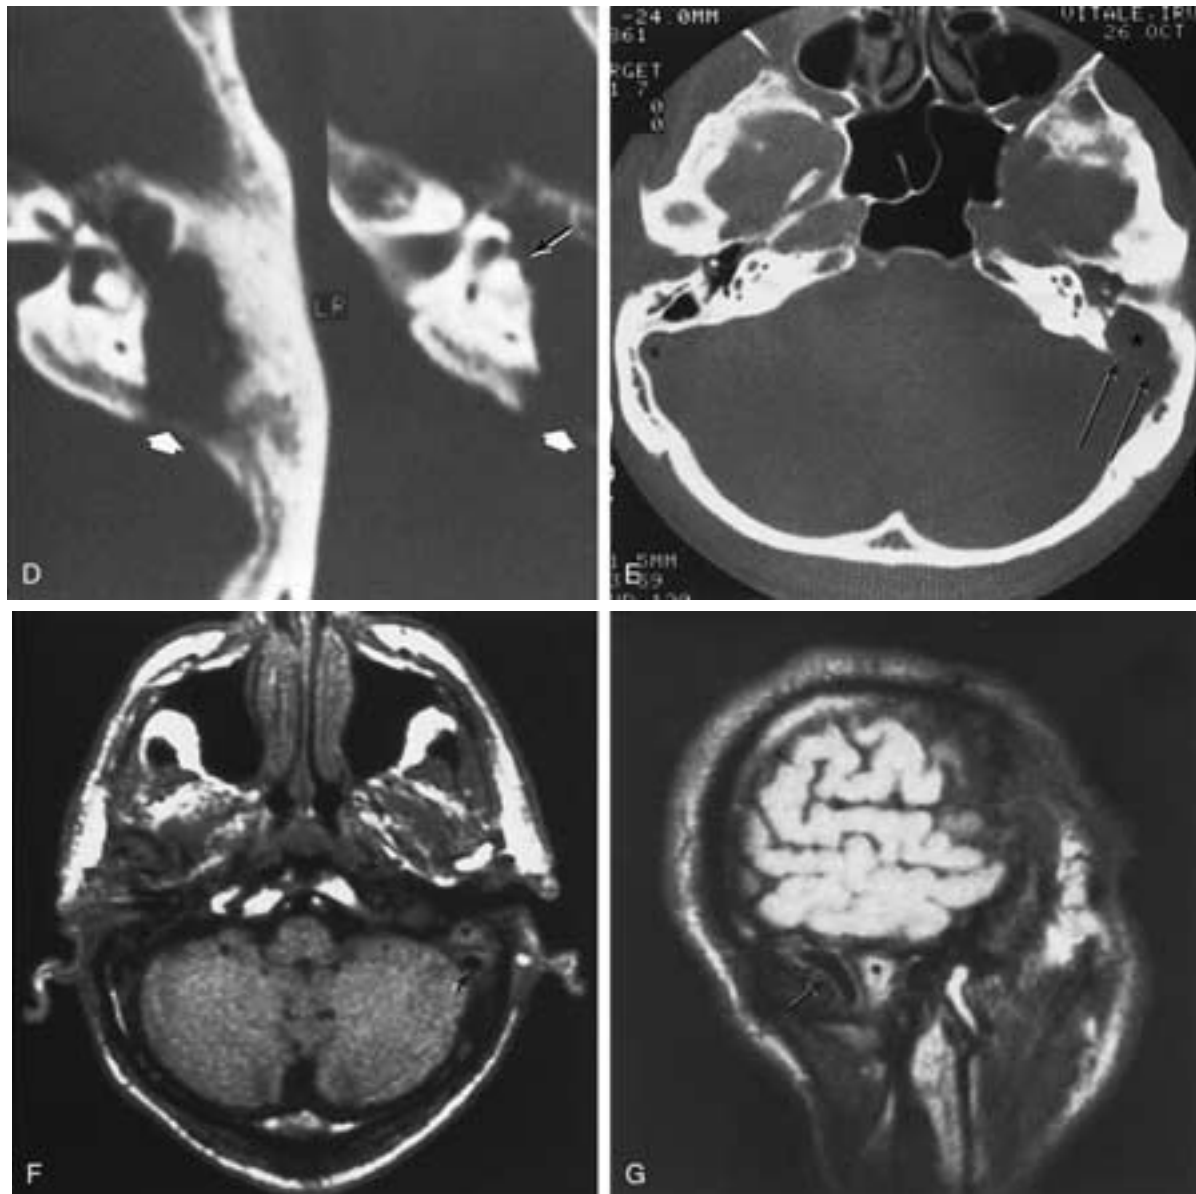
Continued D, In addition to the large fistula (*black arrow*), contiguous axial images demonstrate the presence of a defect in the sigmoid sinus plate (*white arrowhead*). E, Axial CT image on a different patient. Asterisk, Mastoid mass; arrows, sigmoid sinus plate defect. F, Axial T1-weighted MR image on another patient. Asterisk, Mastoid mass; arrows, patent sigmoid sinus, flow void. G, Sagittal T1-weighted MR image. Asterisk, Mastoid mass; arrow, patent sigmoid sinus, flow void.
